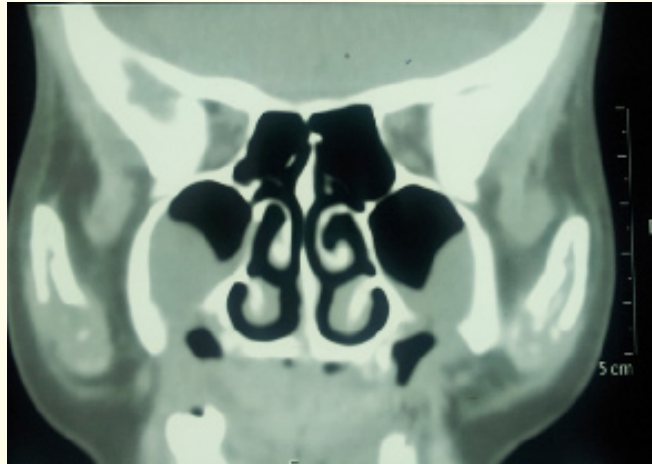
Coronal CT section revealing destruction of the maxillary alveolar bone in the anterior region involving the entire arch along with destruction of the antero-inferior wall of the maxillary sinus bilaterally.
